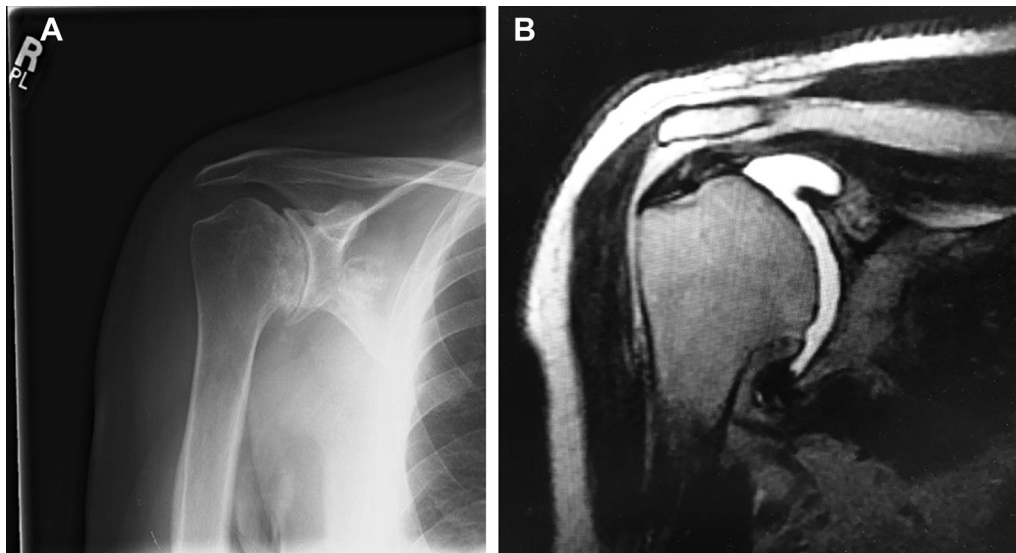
(A) Grashey radiograph of the right shoulder showing significant glenohumeral osteoarthritis. (B) Coronal magnetic resonance image of the right shoulder showing significant arthritis and an intact supraspinatus tendon.
